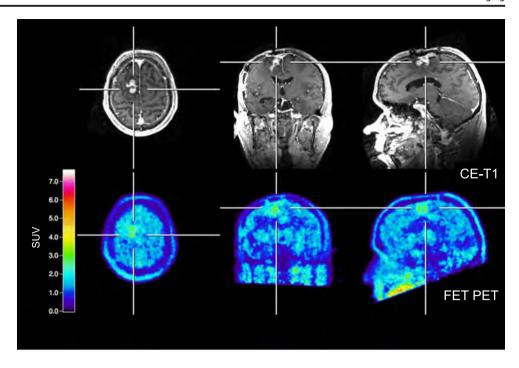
Hybrid PET/MR imaging including a contrast-enhanced T1-weighted images and FET PET images in a 44-year-old man with glioblastoma treated with temozolomide and TTFields (patient 1). In contrast to standard MRI which suggests tumour recurrence (top), the FET PET images show slightly increased tumour-to-brain ratios (TBR_{max} 2.2, TBR_{mean} 1.8) are consistent with posttherapeutic changes (bottom)
